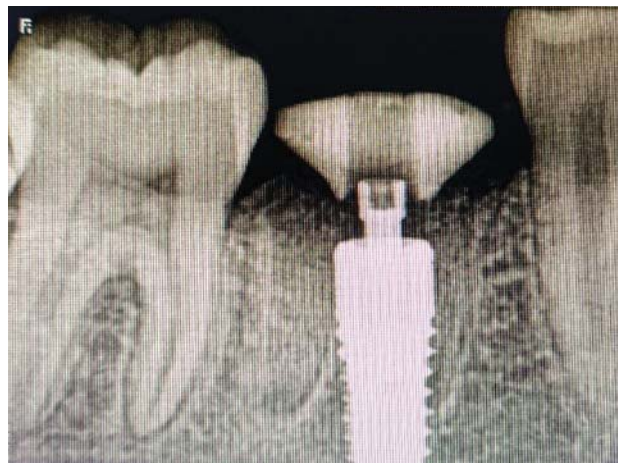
Radiograph after placement of gingival former
